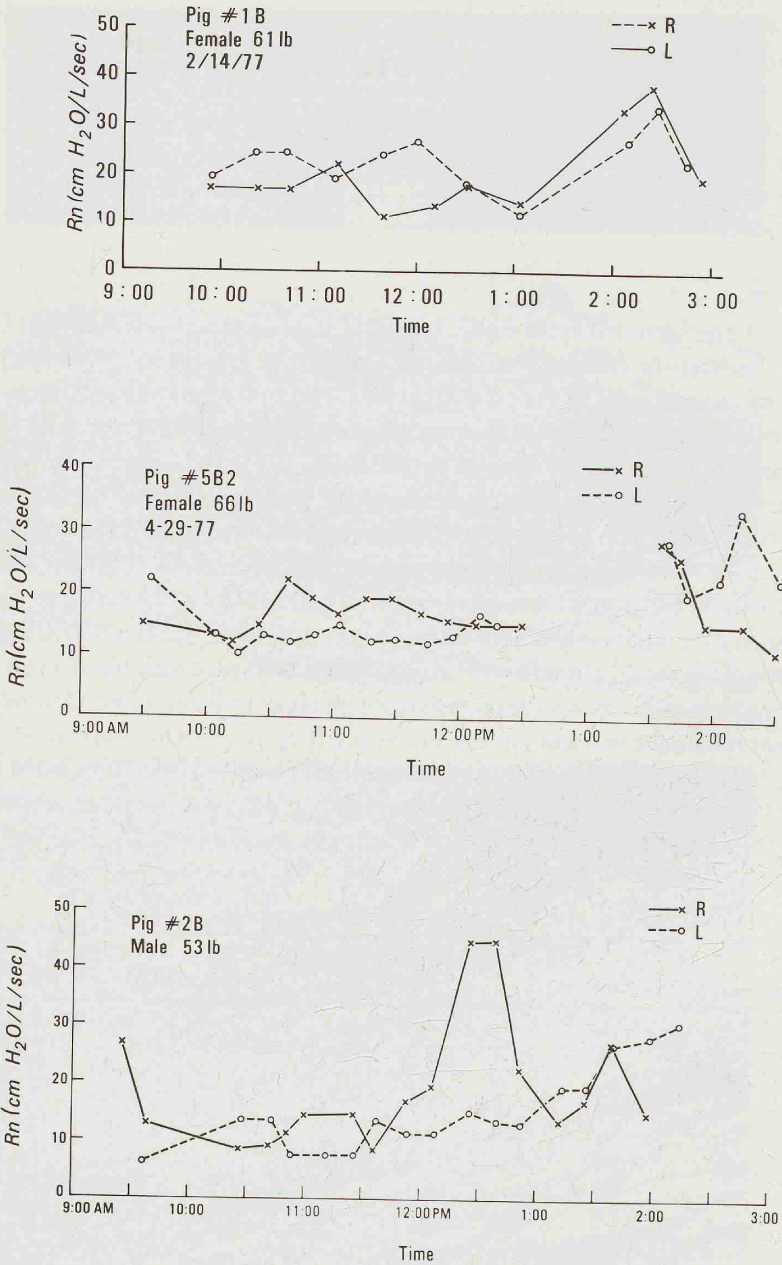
Top*, Cycling at 12:30 p.m. *Middle*, Cycling pattern. (Break in recordings was taken in an attempt to obtain roentgenographs of congested turbinates at this stage of cycle.) *Bottom*, Cycling pattern changes occurred at 10:45 a.m. and 1:10 p.m.
